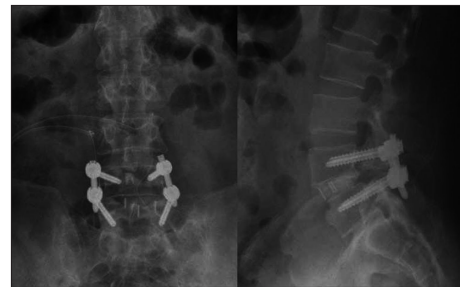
Immediate postoperative radiographs showing a good reduction of the spondylolisthesis and a well-positioned fusion cage.
